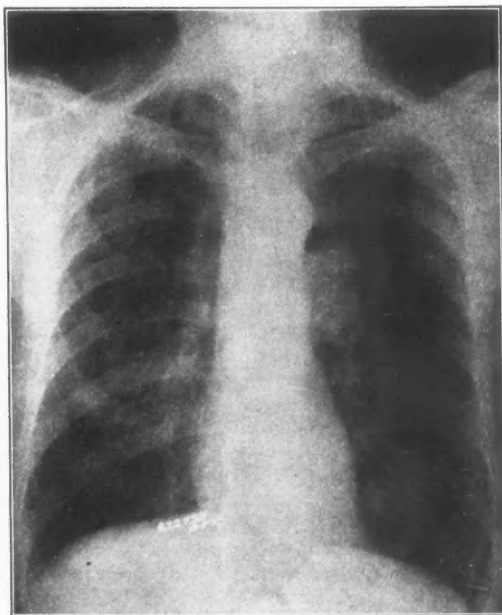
Patient represented in Figure 1 twenty-one days later and two weeks after a course of roentgen irradiation. Marked retrogression of the mediastinal tumor is shown.
